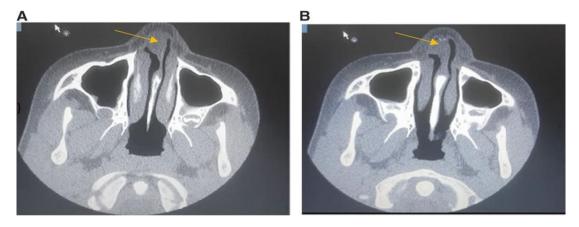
Computerized tomography(CT scan).
